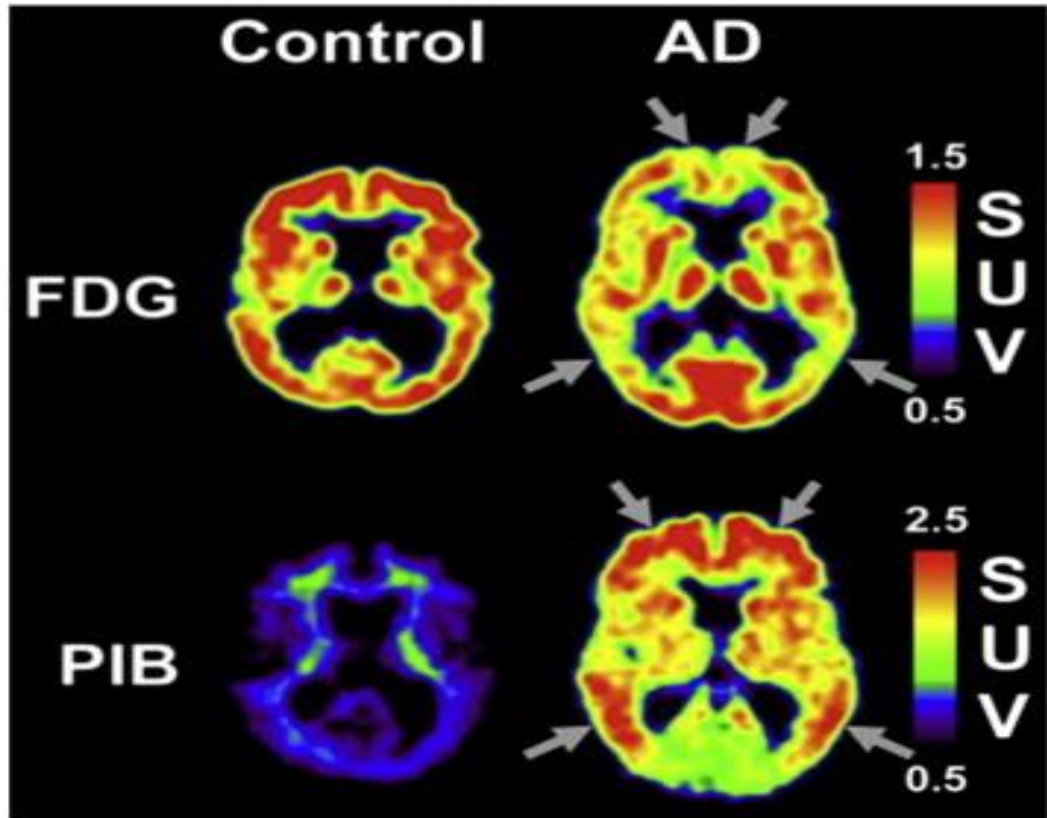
Example of FDG and PiB Positron Emission Tomography: The upper image is an example of fluoro-2-deoxy-D-glucose (FDG) PET imaging. The control demonstrates normal FDG uptake, whilst arrows on the AD image shows a typical pattern of FDG hypometabolism or A $\beta$  deposition. The lower image depicts Pittsburgh Compound B (PiB) PET imaging of A $\beta$  in brain of Control (left) and AD (right), with high A $\beta$  retention observed in AD [108]
